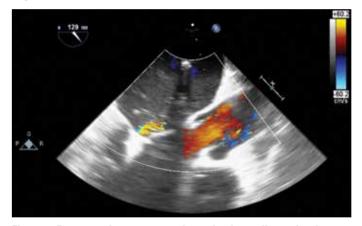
Postprocedure transesophageal echocardiography shows a resolution of the severe mitral regurgitation in the left ventricular outflow tract view
